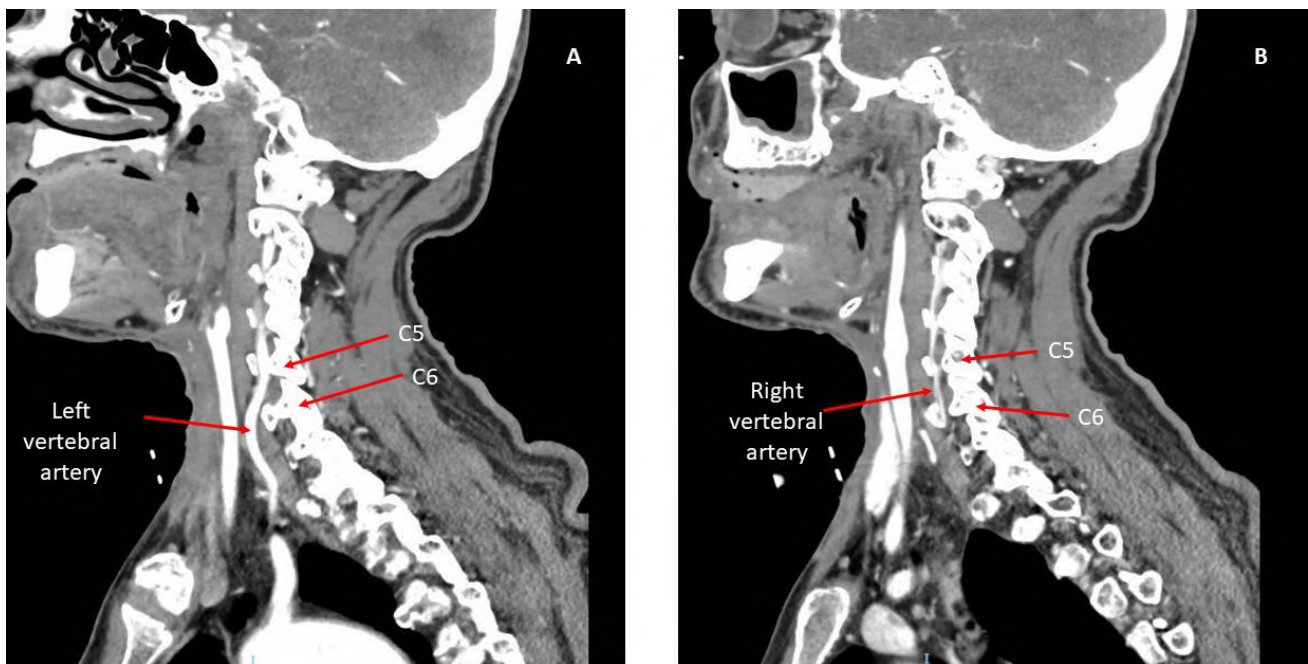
Sagittal CT with arterial intravenous contrast that show the entrance of left vertebral artery in transverse foramina in the fifth cervical vertebra (A) and in the sixth cervical vertebra in the case of right vertebral artery (B).
